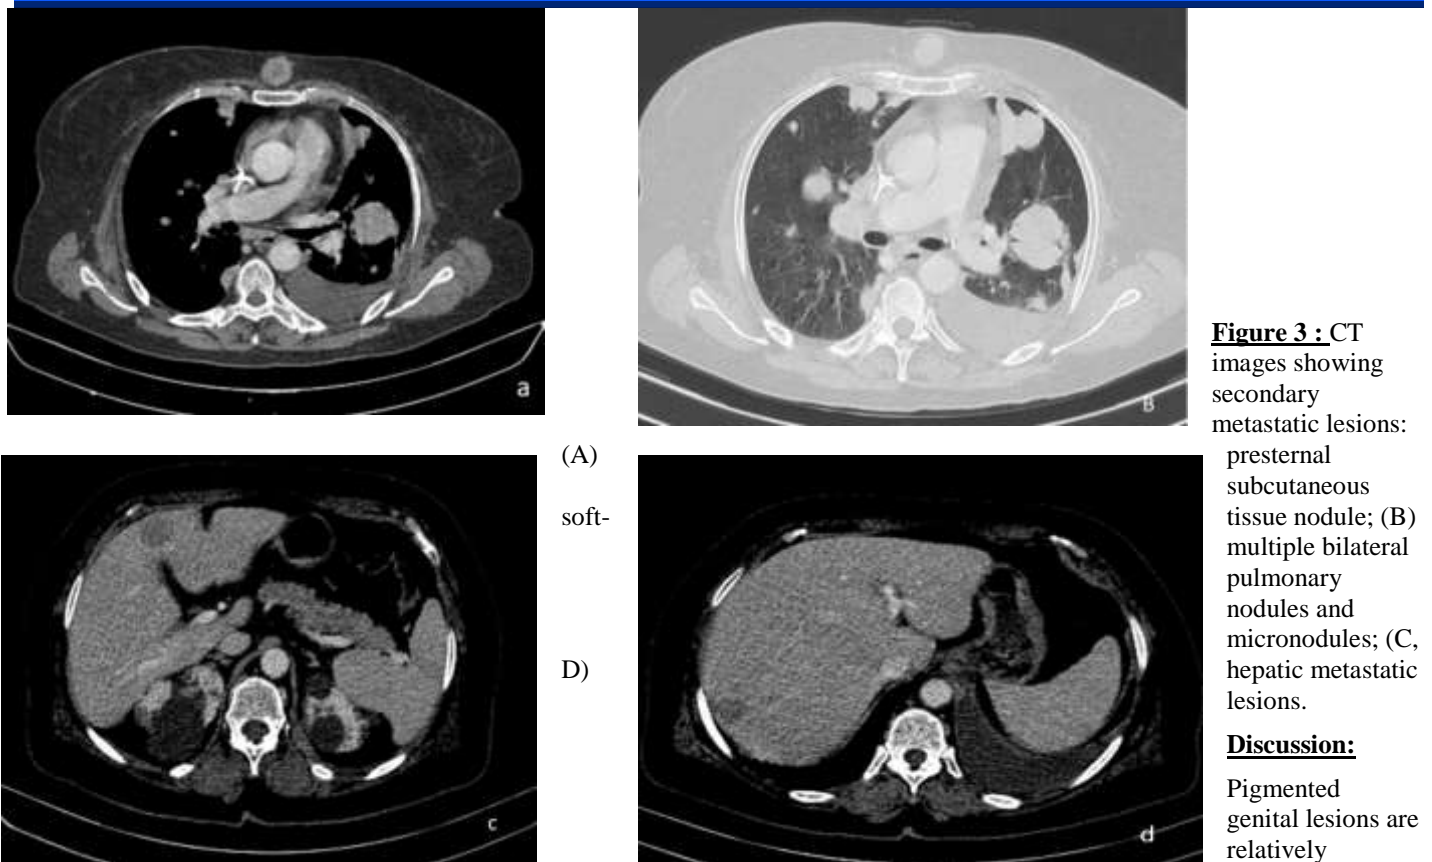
CT images showing secondary metastatic lesions: presternal subcutaneous tissue nodule; (B) multiple bilateral pulmonary nodules and micronodules; (C), hepatic metastatic lesions.
